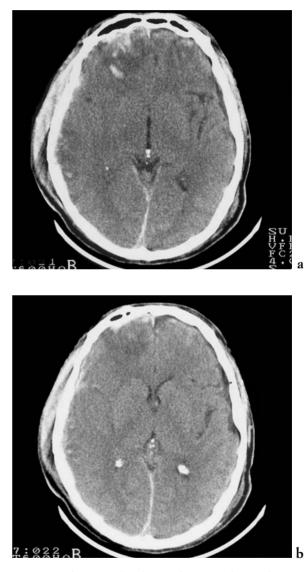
(a-f) Temporal evolution of contusive haemorrhagic focus. (a-b) CT examination a few hours following trauma: irregular haemorrhagic foci are seen in both frontal lobes and in right temporal-parietal region with the obliteration of the ipsilateral Sylvian fissure cistern.
